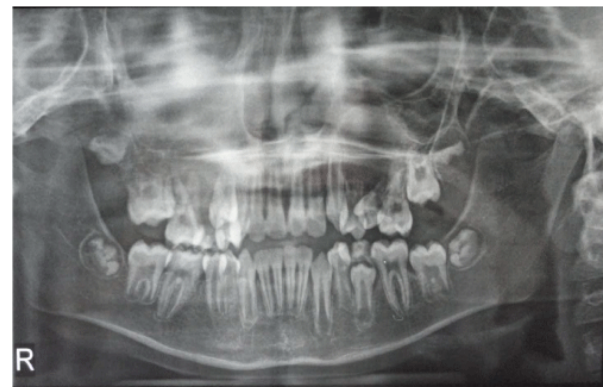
Panoramic radiograph showing solitary lesion with irregular, diffuse ragged borders involving right maxilla
